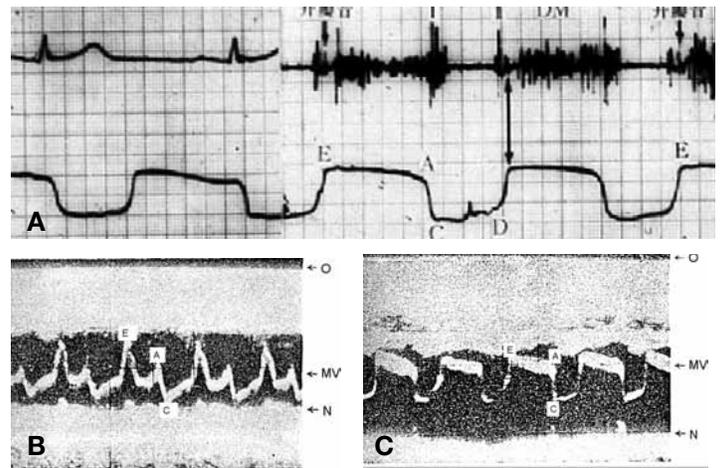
(A) World's first demonstration of coincidence of the E-peak (double-headed arrow) on echocardiogram with the opening snap (arrow) followed by the flat EA (now called EF) slope corresponding to a long diastolic murmur (DM) in a simultaneously recorded phonocardiogram in a patient with mitral stenosis (courtesy XF Wang). (B) Echocardiogram of a normal-sized left atrium in a normal subject. The distance from the closed mitral valve (C) to the posterior wall of the left atrium (N) is the size of the left atrium, which is 8 mm here (courtesy XF Wang). (C) The world's first echocardiographic demonstration of enlarged left atrium in mitral stenosis. The distance from C to N is widened to 22 mm in this patient. Note also the flat EA curve that is typical for mitral stenosis (courtesy XF Wang). O: transmission pulse; MV: mitral valve curve; N: posterior wall of left atrium near atrioventricular ring.
